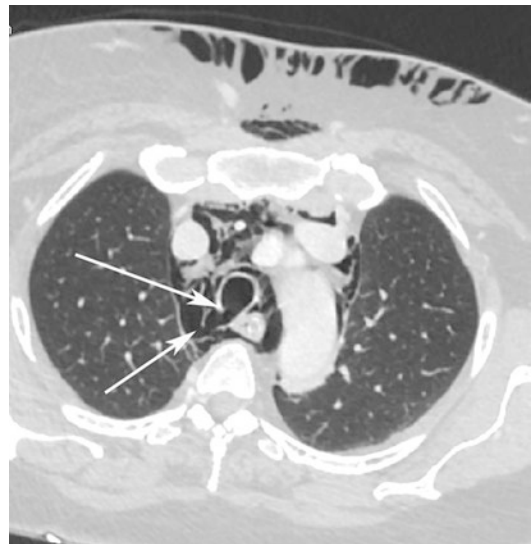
Post-contrast axial CT scan at level of upper mediastinum shows a parietal defect of the posterior wall of the trachea (white arrows), associated with pneumo-mediastinum and subcutaneous emphysema
